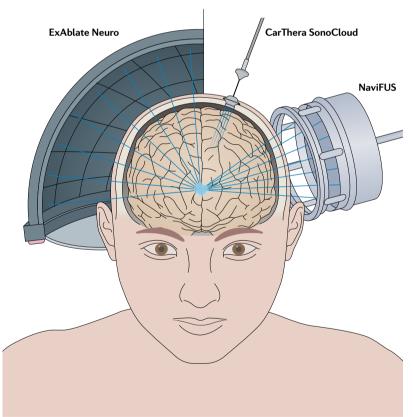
Current therapeutic ultrasound devices for brain applications. The ExAblate Neuro system comprises a phased array of transducers coupled to an MRI system. The elements line the concave inner surface of a helmet that is placed close to the scalp with intervening degassed water. NaviFUS is another transcranial system. Like ExAblate Neuro, NaviFUS is multi-channelled but with fewer elements on a smaller surface area. Navigation of the device is based on pre-procedure imaging. The CarThera SonoCloud implanted ultrasound device is powered through a bipolar needle introduced through the skin for each treatment. The ExAblate Neuro systems are employed for both thermoablation and blood–brain barrier opening whereas NavFUS and CarThera SonoCloud are currently being investigated for blood–brain barrier opening.
